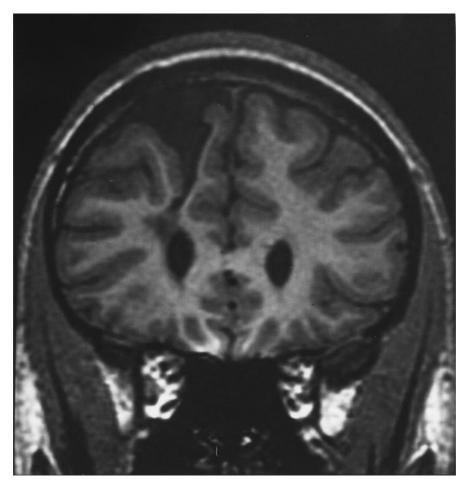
Coronal T_1 -weighted MRI (Ir SPGR) showing schizencephaly that extends to the right lateral ventricle.
